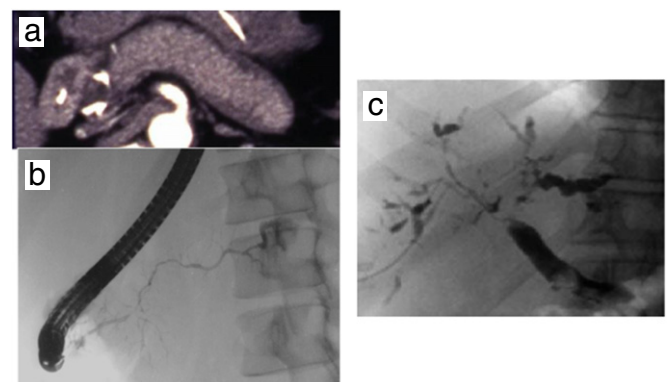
Type 1 AIP. a. Dynamic CT shows diffuse swelling of the pancreas with late phase enhancement and low-density rim. b. Endoscopic pancreatography shows diffusely irregular narrowing of the main pancreatic duct. c. Endoscopic cholangiography shows beaded like and long stenotic biliary duct similar to primary sclerosing cholangitis.
